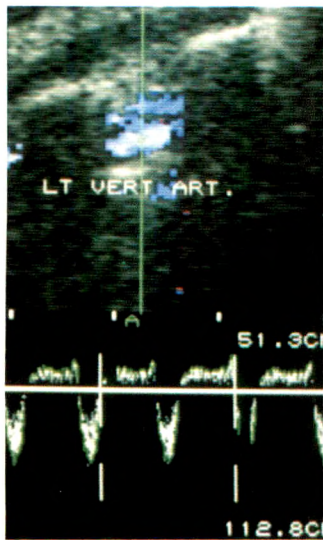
Left subclavian artery stenosis with subclavian steal phenomenon. Real-time color flow sonography shows antegrade flow in vertebral artery in diastole and retrograde flow during systole with flow in vertebral artery and vertebral vein in same direction. Selective spectral waveform demonstrates retrograde systolic flow and antegrade diastolic flow. Antegrade diastolic flow presumably reflects greater resistance of resting extremity circulation in comparison with cerebral circulation.
